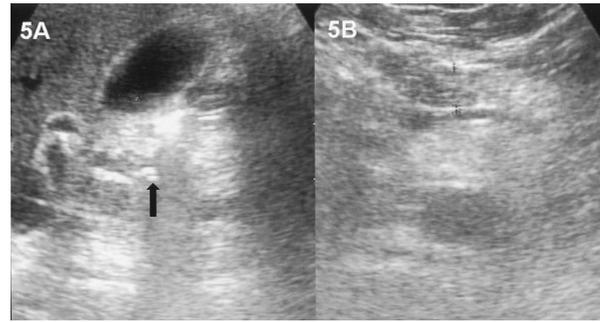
Follow-up trans-abdominal ultrasound revealed a normal caliber of the CBD with the ERBD in situ (5A, black arrow) and disappearance of the pancreatic head lesion (5B).
